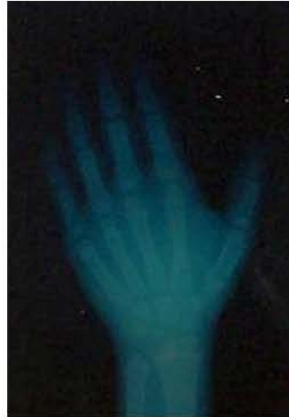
Hand-wrist radiography of a nine-year-old male patient with chronic renal failure
